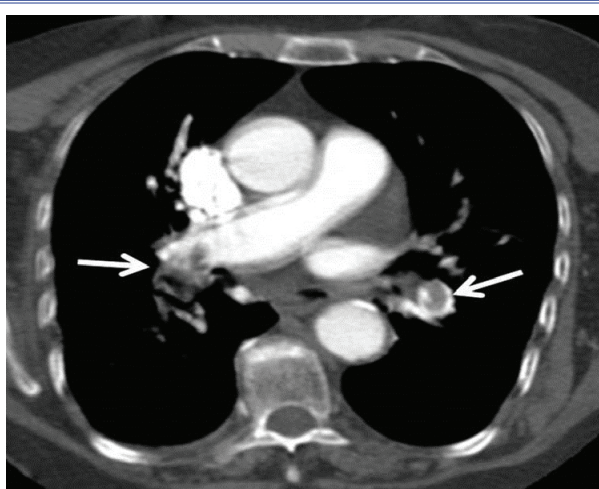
Computed tomographic pulmonary angiogram showing thrombi at bilateral pulmonary arteries (yellow arrows).
